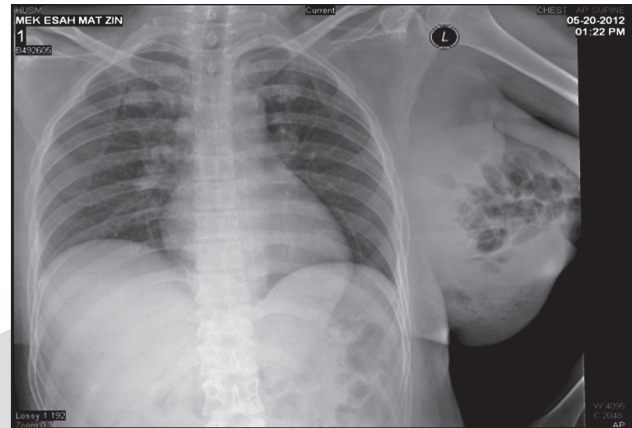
Chest x-ray of breast cancer patient
